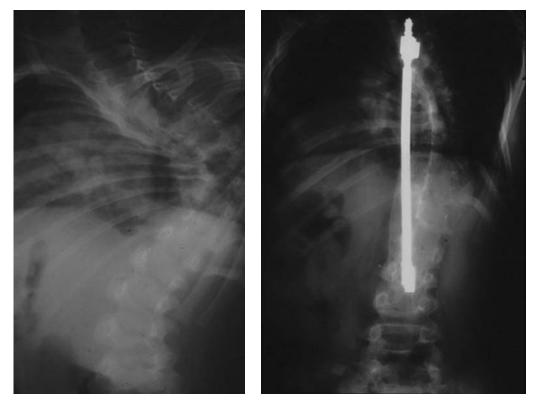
The use of a subcutaneous growing rod. (A) PA X-ray film showing a 100-degree thoracic curve in a boy aged 6 years. (B) PA X-ray film 10 years after anterior multiple thoracic discectomy and the insertion of a growing rod, which was lengthened or exchanged 12 times.
